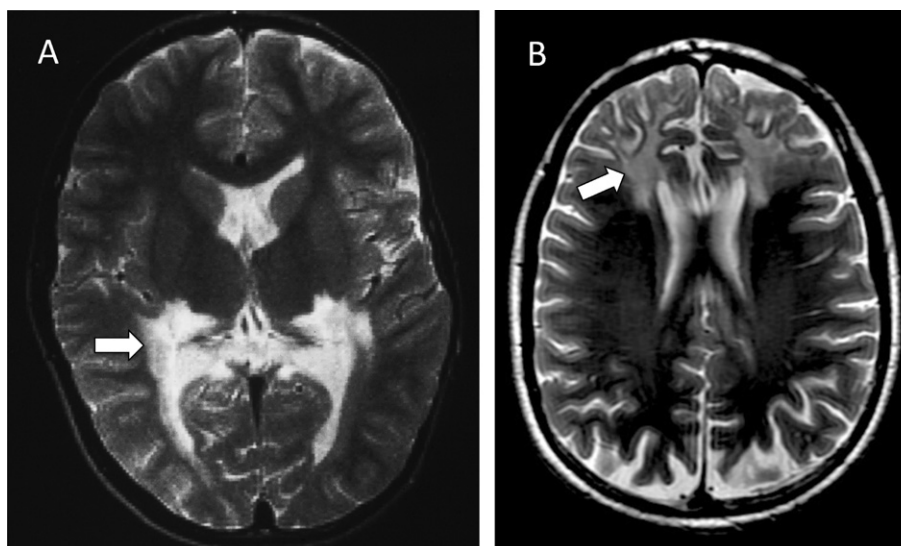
Brain MRI of X-ALD patients with the typical parieto-occipital white matter disease (A) or a more frontal involvement (B). Arrows point to regions of white matter disease on T2-weighted images.
